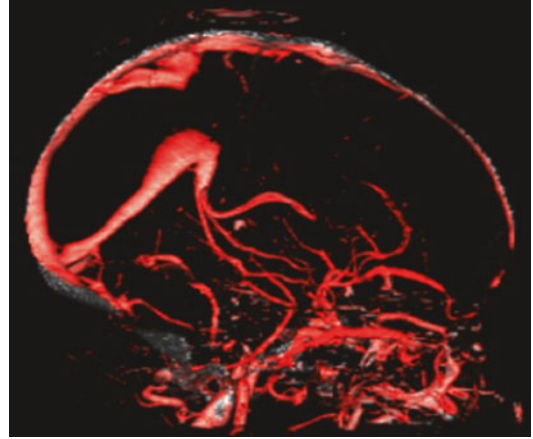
Extreme venous hypertension in 32-year-old female with headaches, papilledema, and high intracranial pressure due to Chiari-related tonsillar herniation that improved dramatically after emergent decompressive surgery; note the dilated plump appearance to the straight sinus on this preoperative CT venogram study
